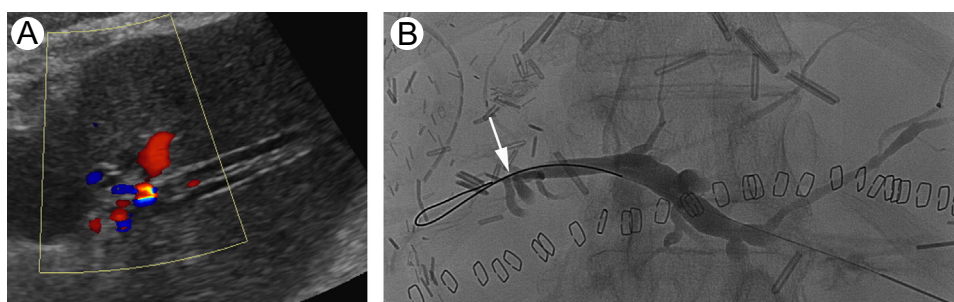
Images from a 68-year-old female recipient of a living donor left lobe liver transplant that was performed 2 years ago who developed an elevated alkaline phosphatase level. US with Doppler image (A) demonstrates intrahepatic biliary ductal dilatation. Percutaneous cholangiogram (B) demonstrates intrahepatic biliary ductal dilatation and narrowing at the site of the biliary-enteric anastomosis (arrow). (Color version of figure is available online.)
